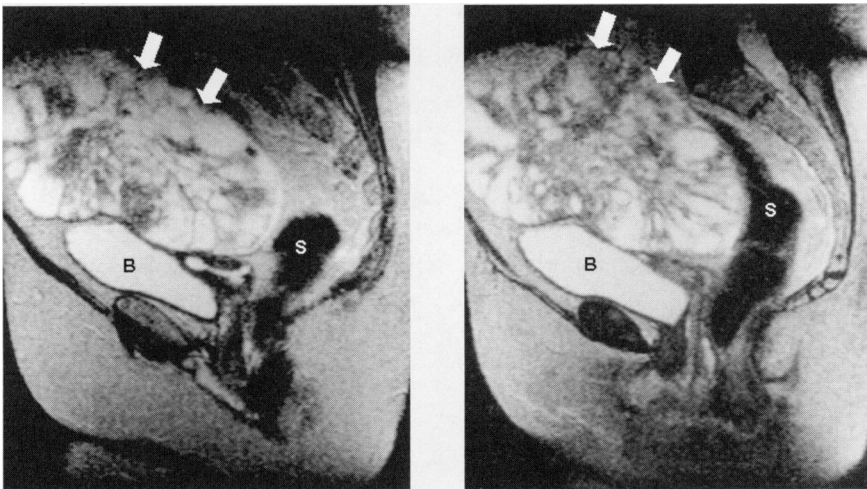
Sagittal pelvic MRI scans revealing a large, irregularly shaped pelvic mass (arrows) in close proximity to the bladder (B) and sigmoid colon.
